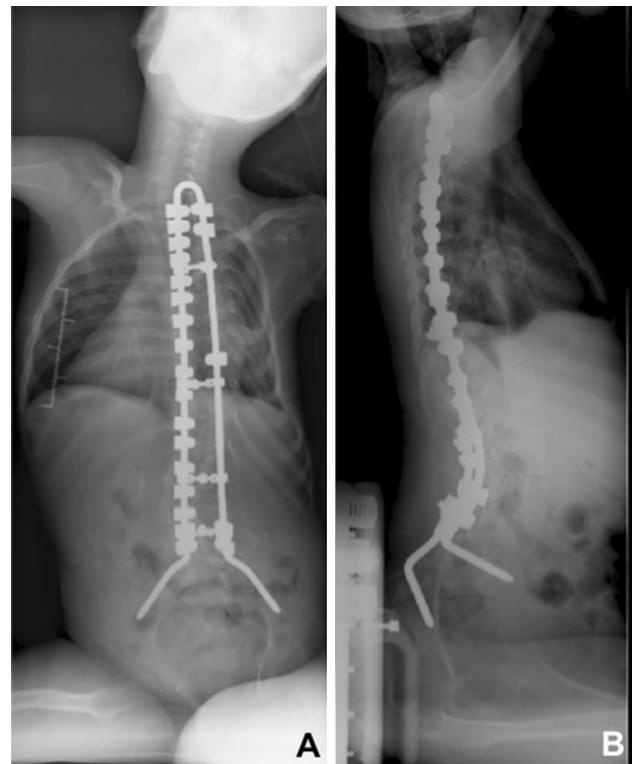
Postoperative radiography and spine fusion with modified Luque–Galveston technique
